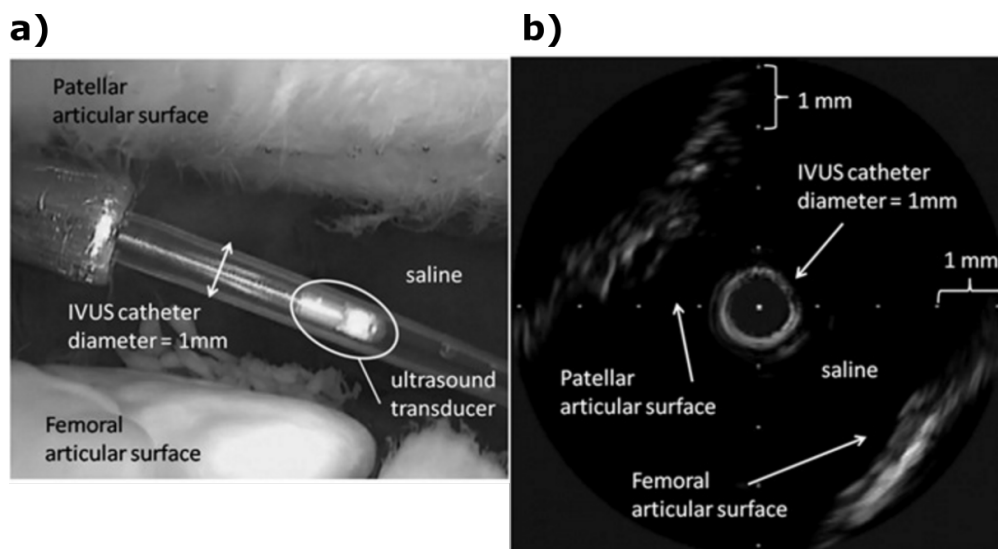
Images of arthroscopic video (a) and intra-articular ultrasound (b) during an *in vivo* application of IAUS. Patellar and femoral articular surfaces are visible. The femoral surface appears more fibrillated. Reprinted from [13] with permission from Sage.
